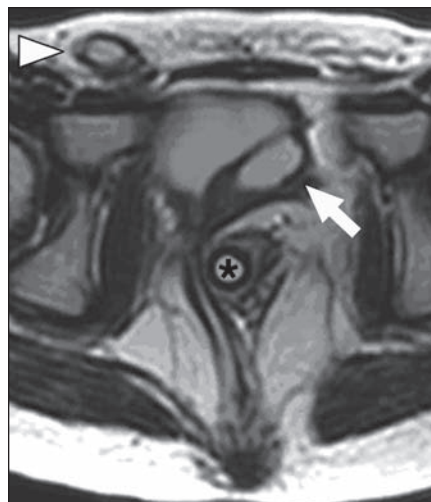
4-year-old boy with multiple genitourinary anomalies after repair of high anorectal anomaly (rectal–bladder neck fistula). Axial T2-weighted MR image of pelvis shows left hemibladder (arrow) and right undescended testis (arrowhead). Fairly developed sphincter mechanism and eccentric location of rectum on left side in relation to sphincter are evident. Asterisk indicates Foley catheter within bowel lumen.
